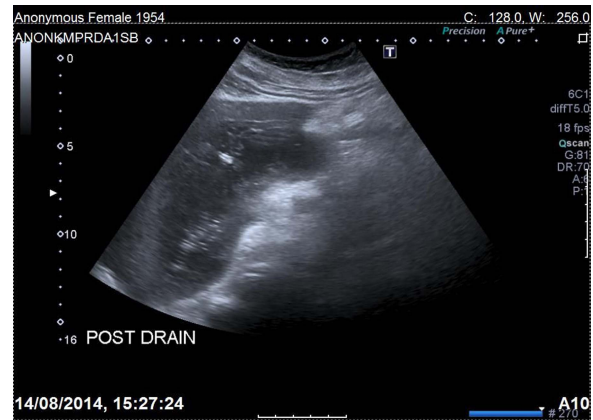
Ultrasound image of subcapsular haematoma following percutaneous drainage.
